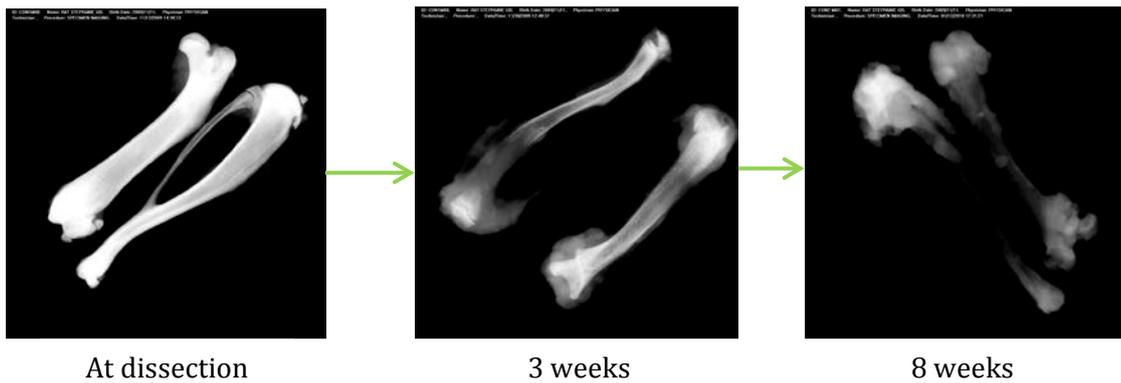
X-ray images of the same femur and tibia at different stages of demineralisation. Fully mineralised on the left through to demineralised on the right.
